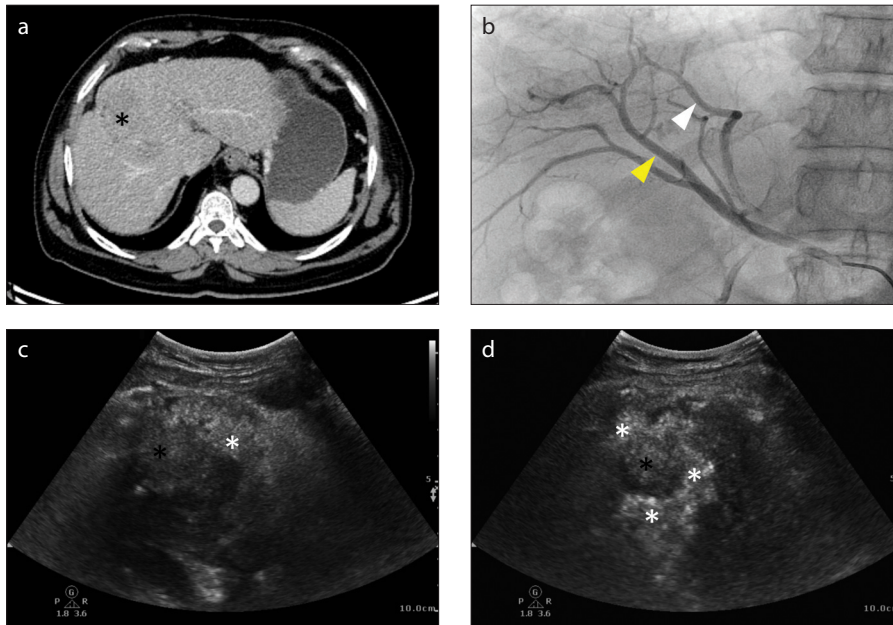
a–d. Contrast-enhanced CT scan of the liver. Axial section (a) shows a subtle hypovascular lesion (*asterisk*) in the segment VIII of right lobe. Right hepatic angiography image (b) shows two major superiorly directed vessels (*white and yellow arrowheads*) coursing towards the suspected lesion location. US image (c) of the right lobe taken during injection of blood-saline-air mixture into the medial of the superiorly directed branches shows echo enhancement of liver parenchyma (*white asterisk*) away from the lesion (*black asterisk*); and the same section taken during injection into the lateral of the branches (d) shows enhanced reflectivity of the parenchyma around the tumor (*white asterisks*) and mildly enhanced reflectivity of the tumor (*black asterisk*).
